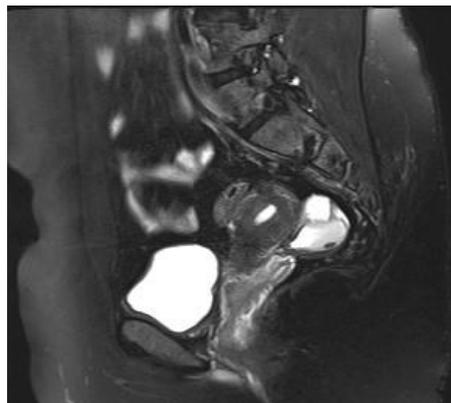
Sagittal T2-weighted fat-suppressed image shows a well-defined cystic lesion measuring ~ 3.2x3x2.2 cm in the left ovary. A T2 hypointense nodule is seen within it, representing a 'T2 dark spot'. The T1 hyperintense lesion appears as T2 hypointense, thus representing 'T2 shading'. Uterus appears normal in size and mildly retroverted.
